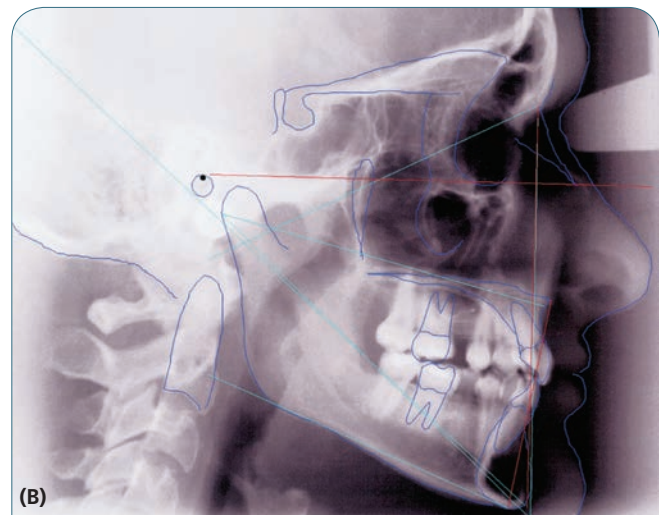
(A) Cephalometric radiograph. (B) Cephalometric tracing on a radiograph. (Courtesy of Dr. Steven Gregg.)
